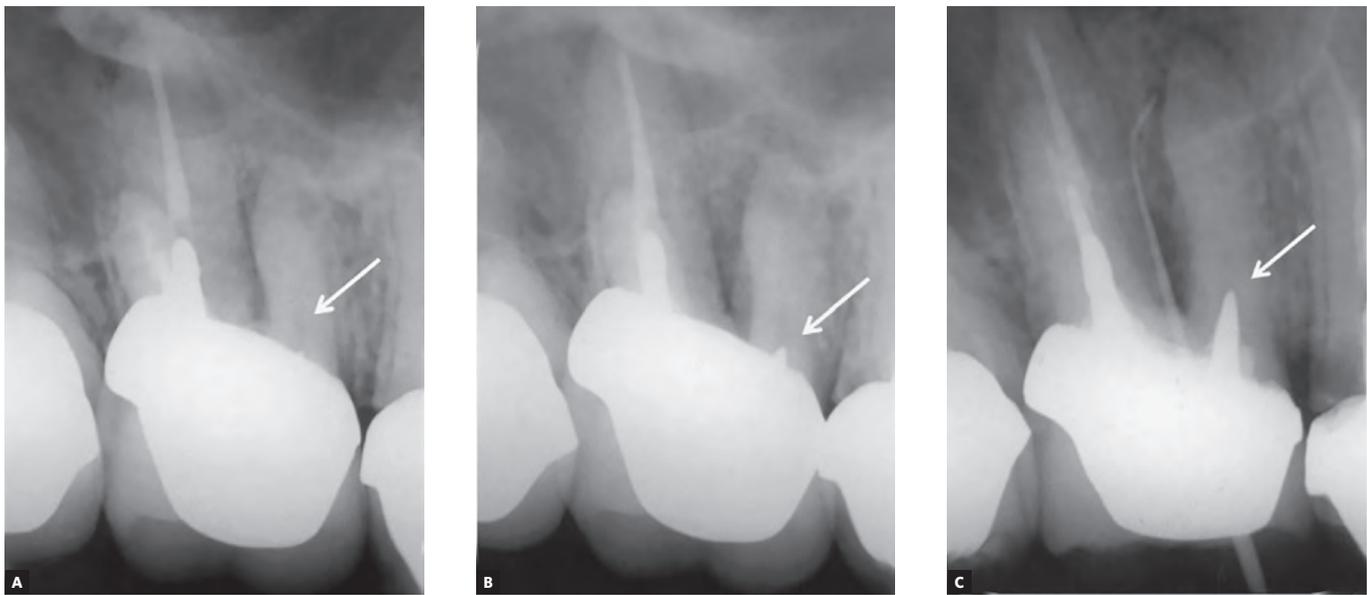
Conventional radiograph of (A) an upper molar in which an intraradicular post can not be observed in the mesial root. Radiographic images taken with vertical angle reduction (B, C), where the intraradicular post of the mesial root can be observed.
